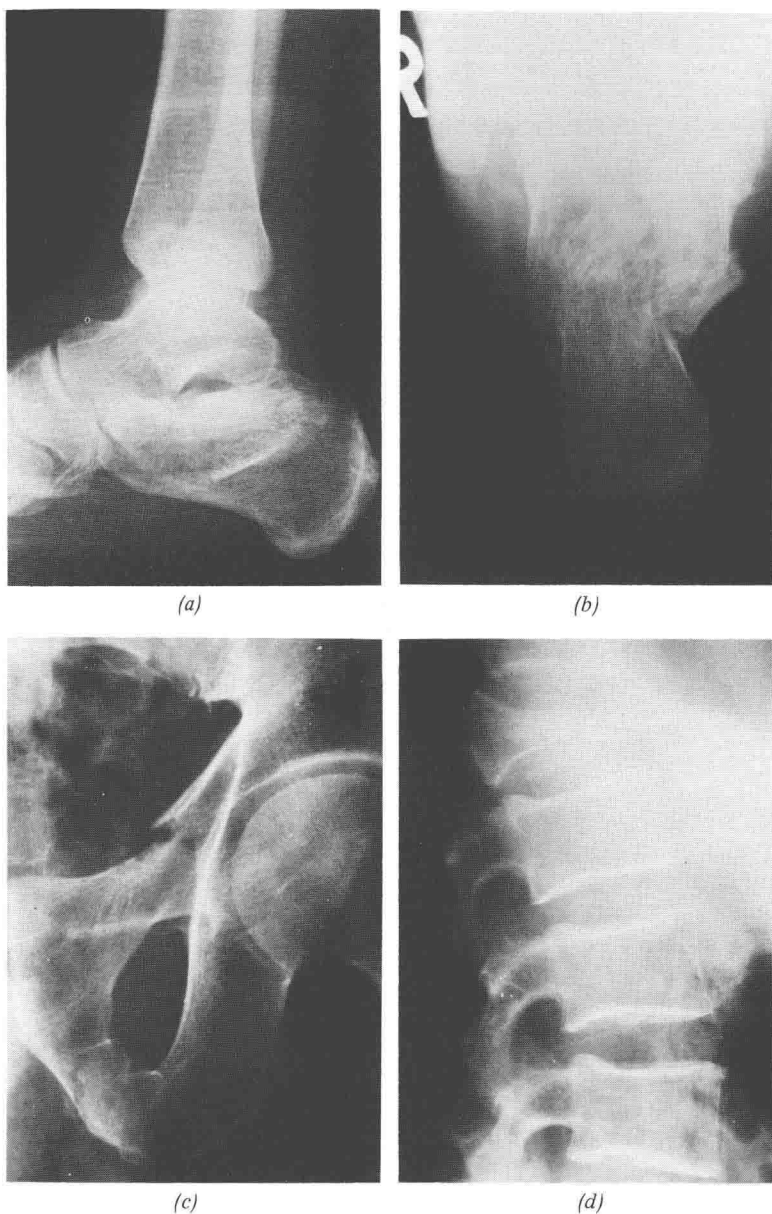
X-Rays of a patient who fell 7 metres from a roof and landed on his heels. (a) and (b) Fractures of the os calcis. (c) Fracture of the hip. (d) Fracture of the lumbar spine
